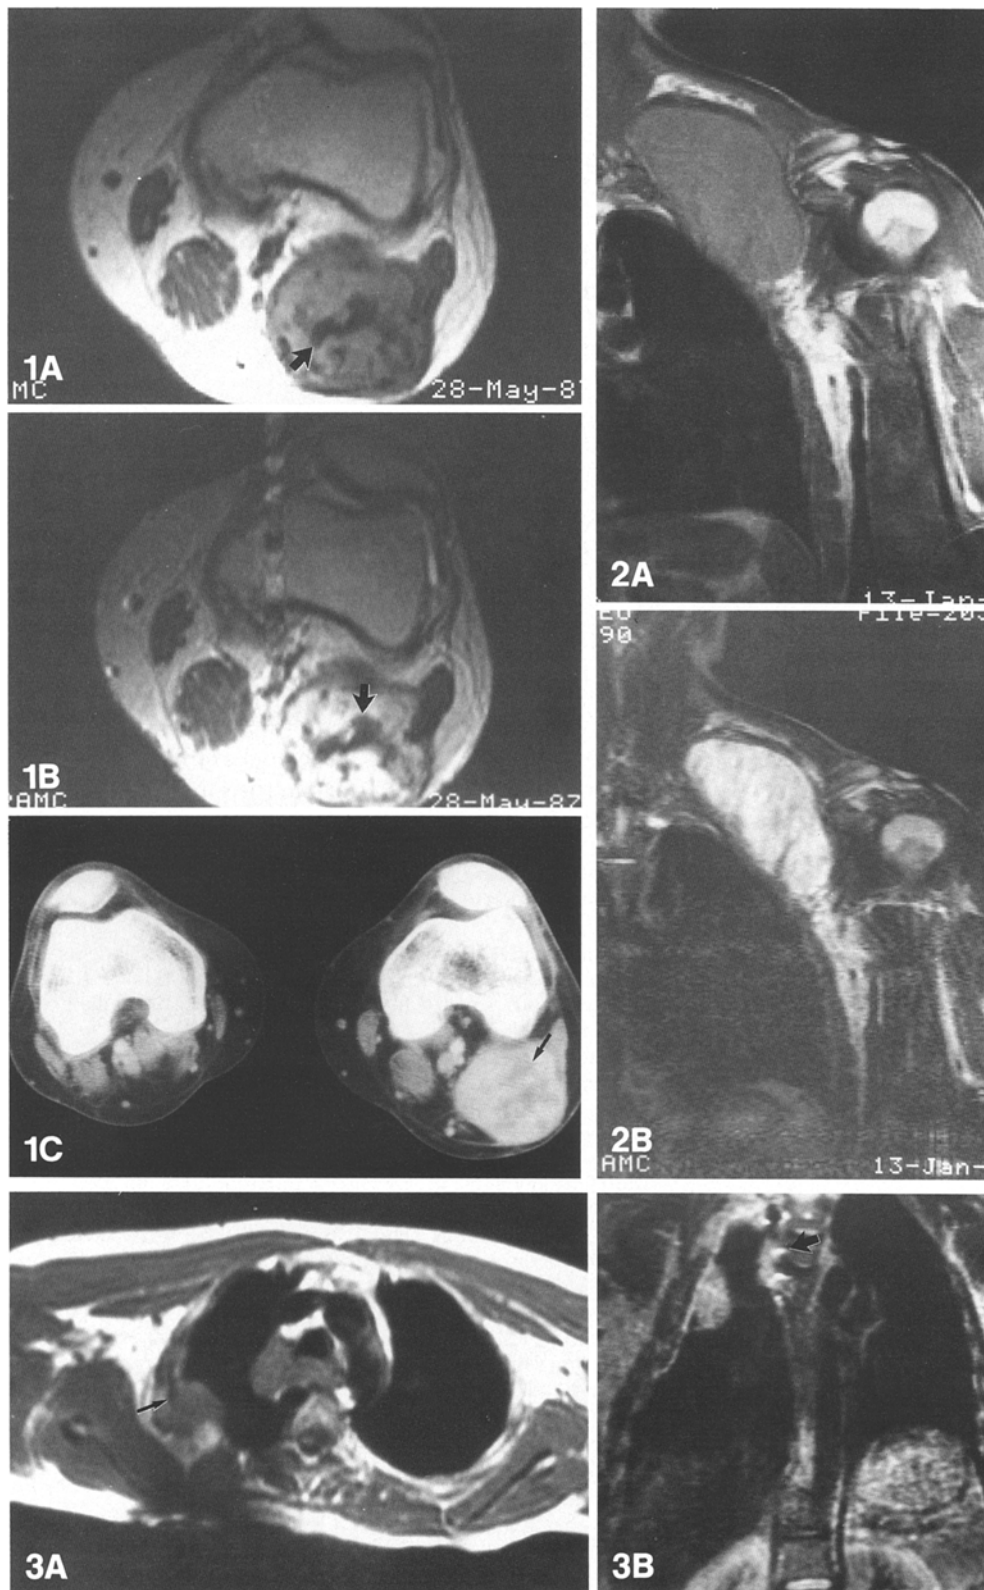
Fibromatosis of the popliteal fossa, 22-year-old man. Axial T₁-weighted (700/34) (A) and T₂-weighted (2000/80) (B) MR images show a relatively well-defined, soft-tissue mass in the popliteal fossa. Within the mass, note areas of decreased/absent signal (arrows) on both pulse sequences. C Corresponding contrast-enhanced axial CT. Note lack of enhancement in the center of the mass (arrow) in a distribution corresponding to the signal voids seen on MR
